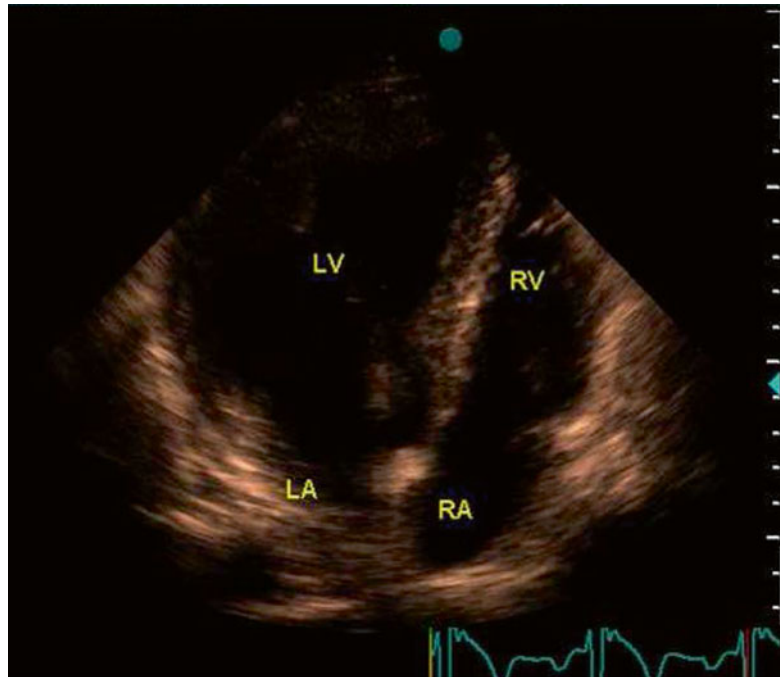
Transthoracic echocardiography in four-chamber view, showing an L-loop ventricle and a concordant atrioventricular connection. *LV* left ventricle, *RV* right ventricle, *RA* right atrium, *LA* left atrium
